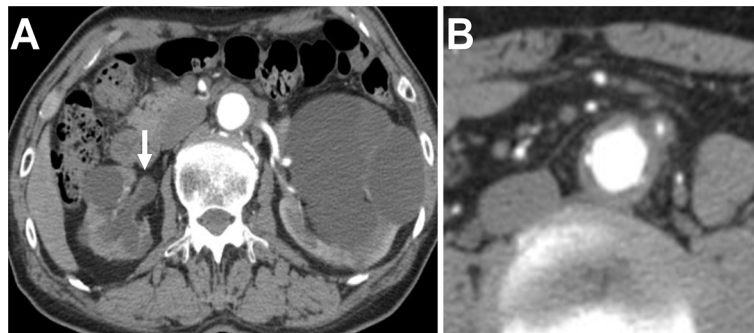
Hydronephrosis and periaortic/periarterial lesion in one participant with elevated serum IgG4 level. Contrast-enhanced computed tomography (CT) imaging showed right hydronephrosis (A, arrow) and periaortic/periarterial wall thickening of the abdominal aorta and its major branch (B)
